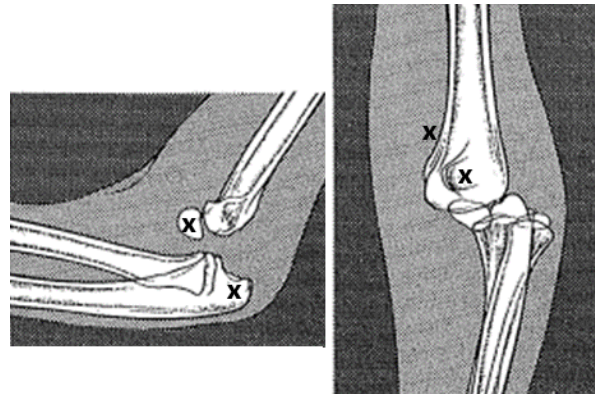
RADIOGRAPHS OF ELBOW DISLOCATION showing mal-alignment of the 3 bony points.
